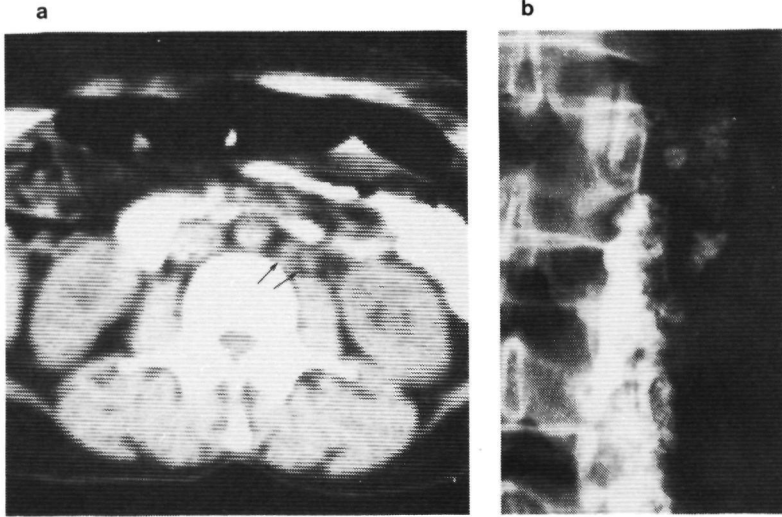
Left-sided para-aortic nodes (arrows) of 1 cm diameter, interpreted with CT as normal (1a). Lymphography demonstrates lymphomatous appearance (1b).
